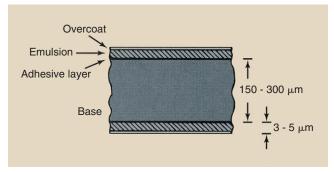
Cross section of radiographic film. The bulk of the film is the base. The emulsion contains the latent image, which becomes visible when processed.
